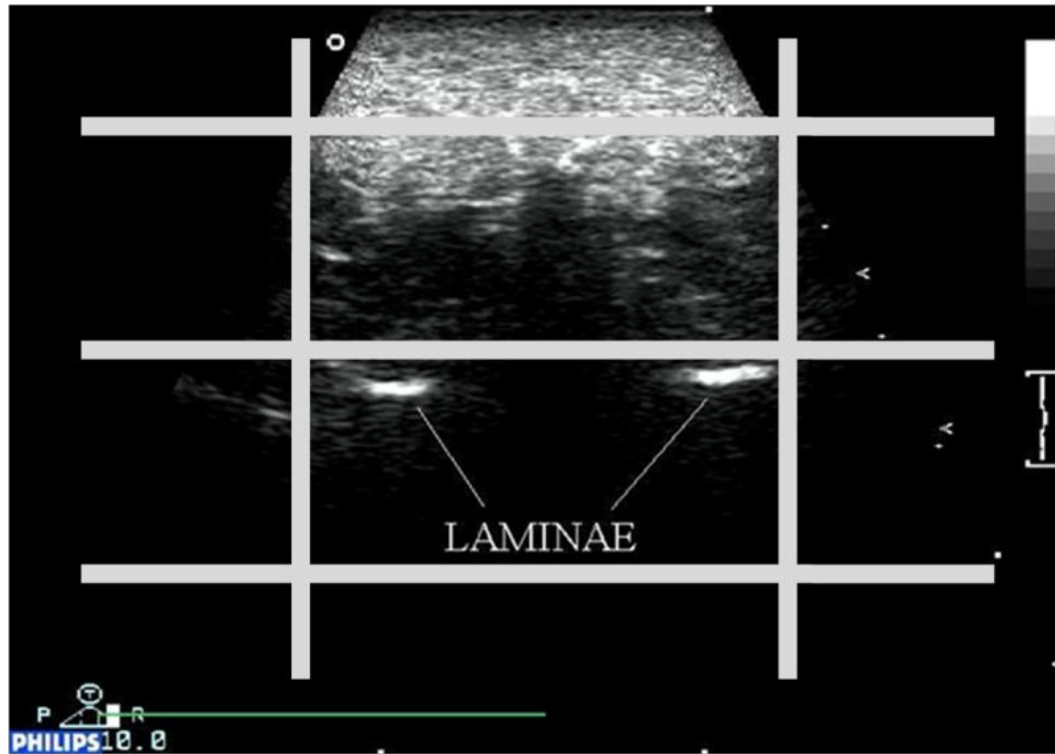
Ultrasound image of laminae in relation to reference lines on the monitor screen
